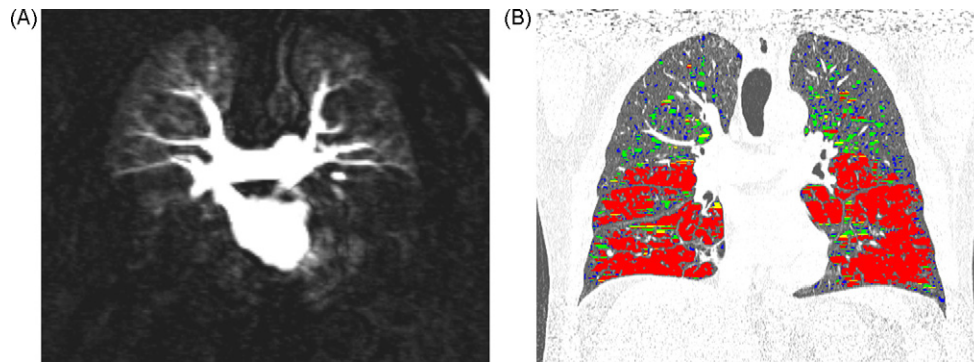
Sixty years old male patient suffering from severe emphysema GOLD class 4 (FEV_1 predicted 25%) with smoking history of 48 packyears. Ten millimeters ventral and dorsal Dataset_{MIP} of coronal lung perfusion MR images (A): the upper lobe was scored 1 for both lungs. The middle lobe and lingula were scored 3 for right and 4 for left lung. We scored the both lower lobes 4. Color map of coronal CT image (B): clusters class 4 (red), class 3 (yellow), class 2 (green) and class 1 (blue). The upper lobes were scored 1 and 2 and the lower lobes 3 and 4 for right and left lung, respectively. The middle lobe and lingula were scored 4 on each side.
